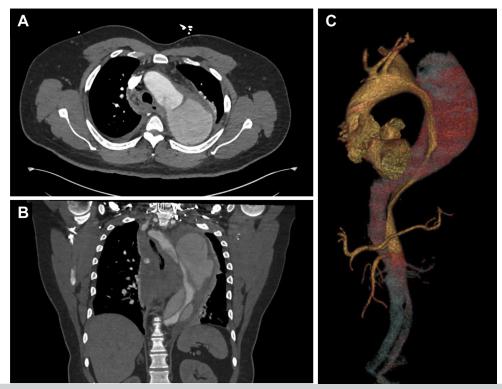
Preoperative computed tomography angiogram (CTA) demonstrating a 7.9-cm ruptured type B aortic dissection (TBAD). A, Axial configuration showing an intimal tear with contrast filling a large false lumen. B, Coronal configuration showing true lumen compression and increased soft tissue density in the mediastinum. C, Three-dimensional reconstruction showing variant arch branching anatomy, including a bicarotid arterial trunk, left subclavian artery, and an aberrant right subclavian artery.
